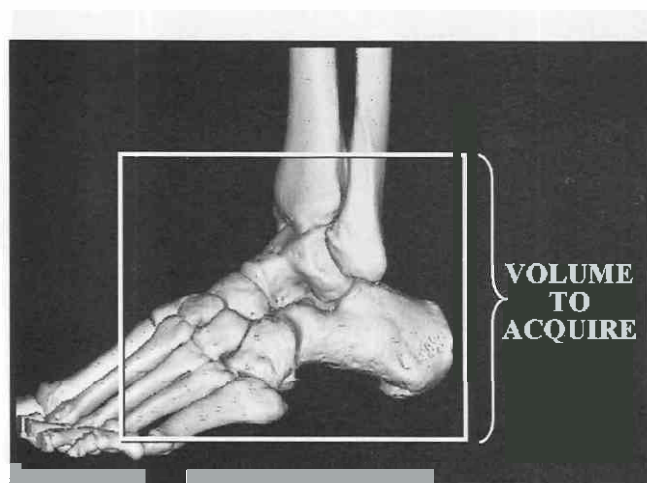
Acquisition volume for CT of the ankle.
